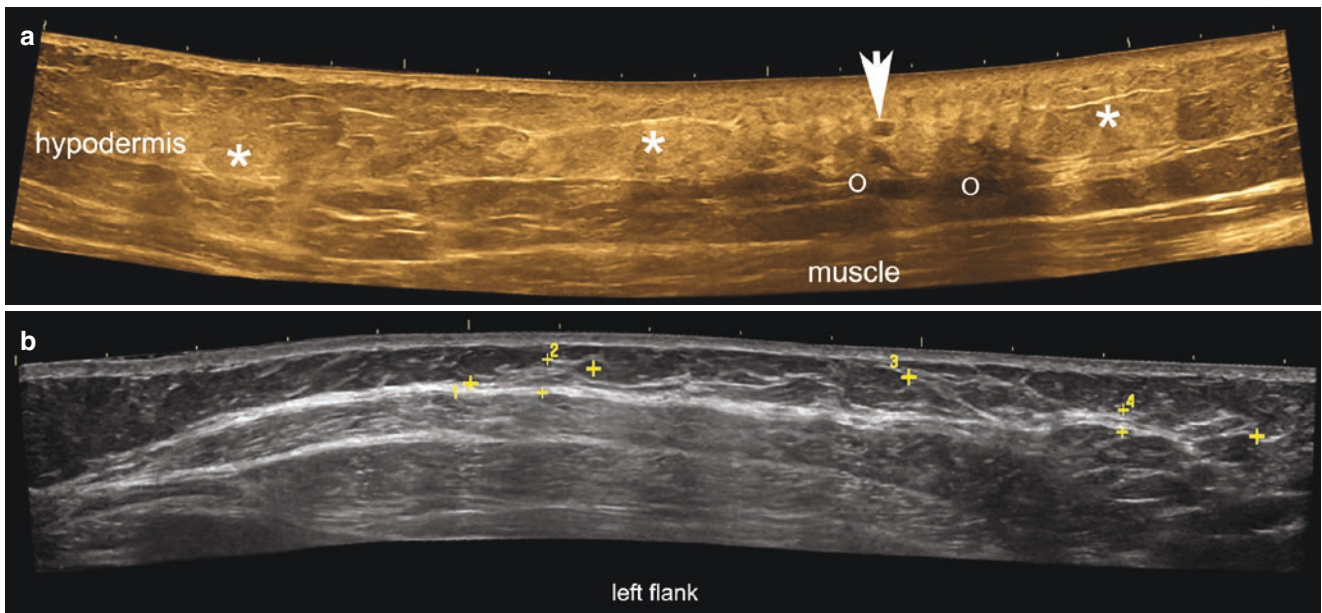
Liposuction. (a) Ultrasound (greyscale, color filter; inner aspect of the right thigh) shows areas with increased echogenicity of the hypodermis (*asterisks*), a round-shaped anechoic structure (*arrow*) that corresponds to focal liquefaction of the fat, and areas with posterior
